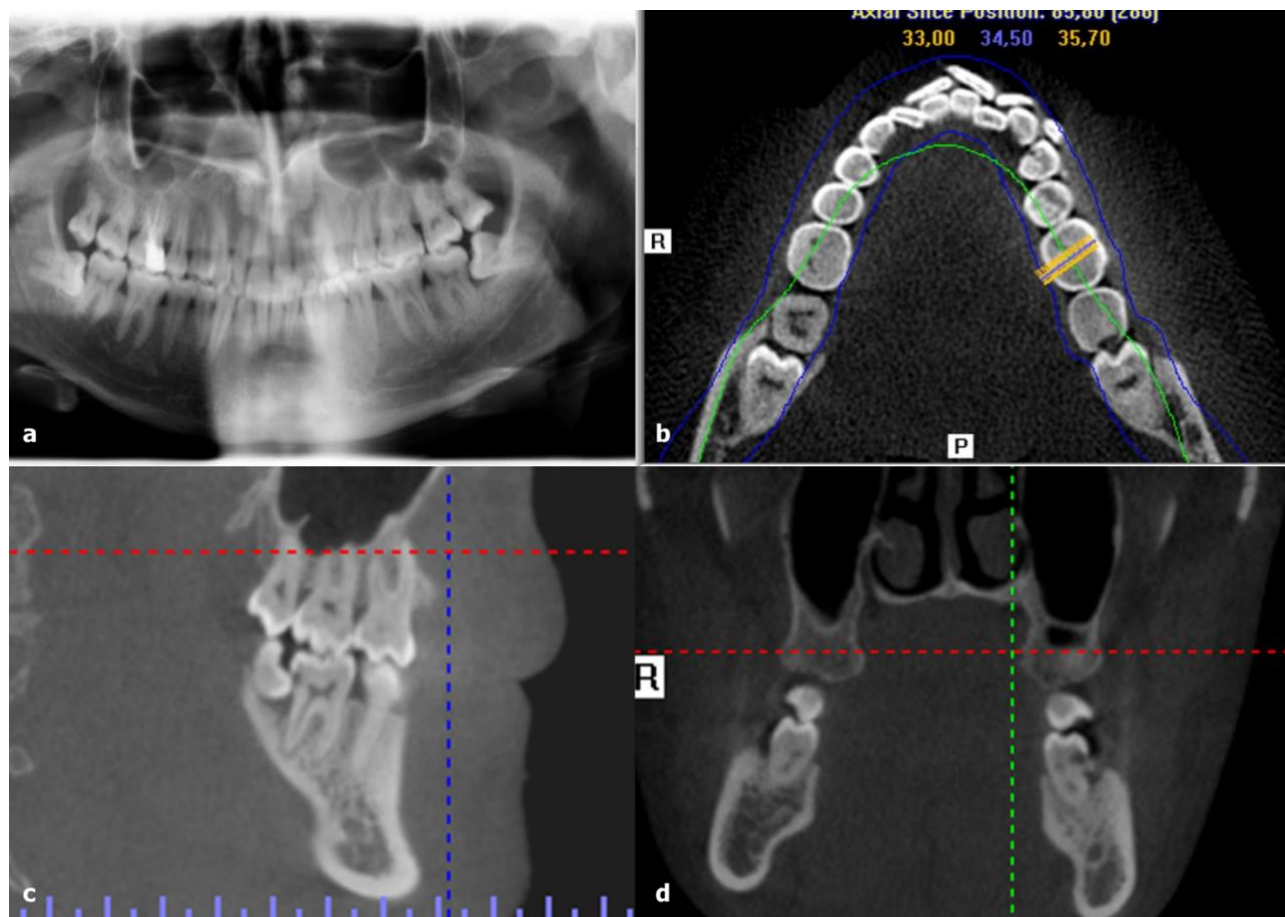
PR and CBCT images of the distal caries in tooth no. 38. (a) PR image of the distal caries in tooth no. 38, (b) axial section, (c) sagittal section, and (d) coronal section.
